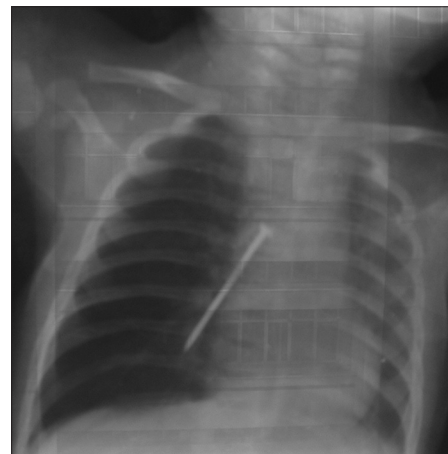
Chest X-ray posteroanterior view showing a nail in right main bronchus
